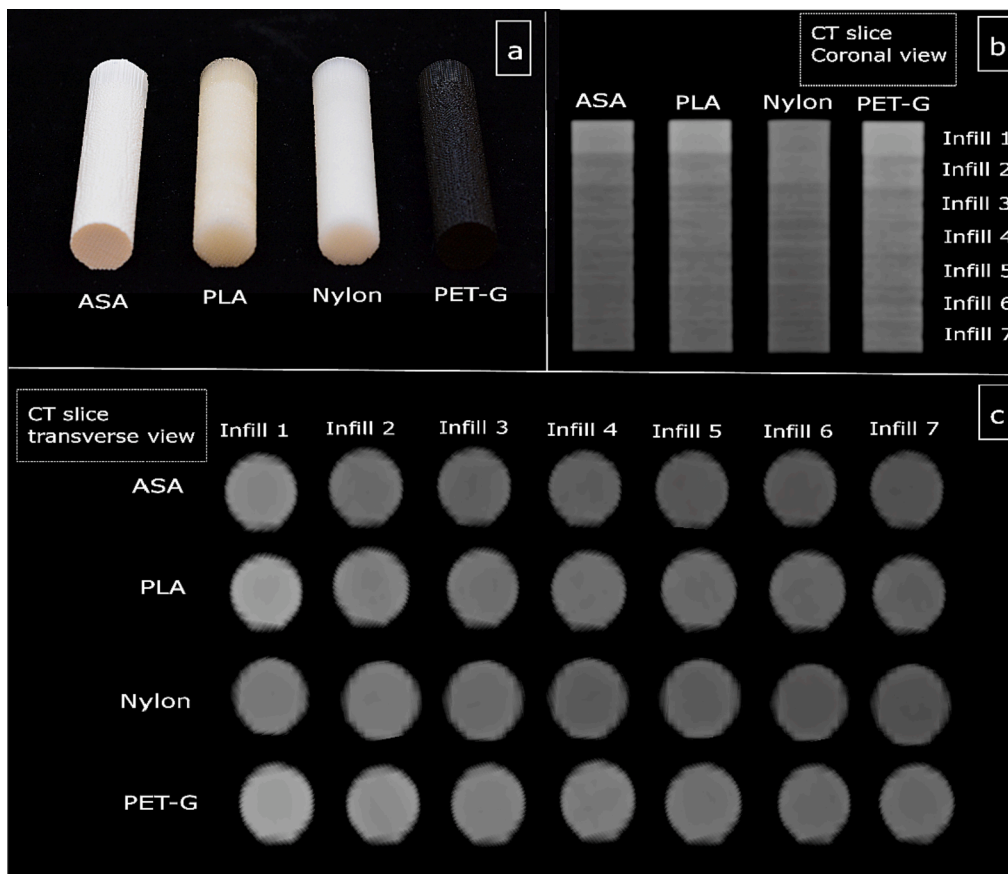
(a) The printed cylinders with four different materials including ASA, PLA, Nylon and PETG. Coronal and transverse views of the CT image from four printed cylinders at different infill densities.
